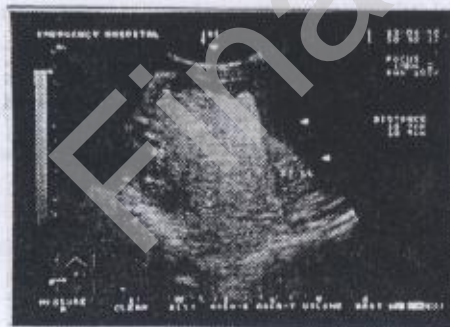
Ultrasonography of a ruptured HCC showing the mass in the right lobe with hyperechoic areas of blood around .
